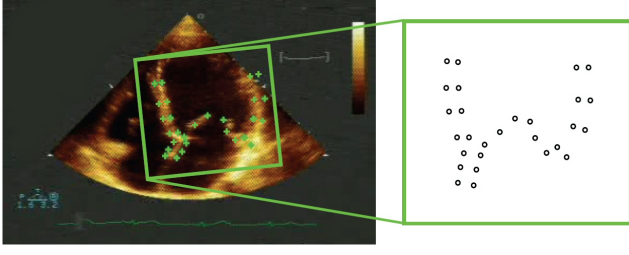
ASM feature points for apical 4 chamber view. (Best viewed in color.)
